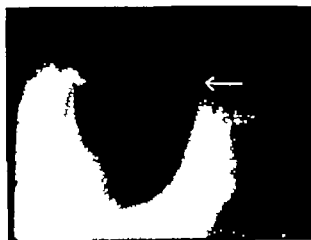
Roentgenogram of patient with floating gallstones, taken in the erect position.
